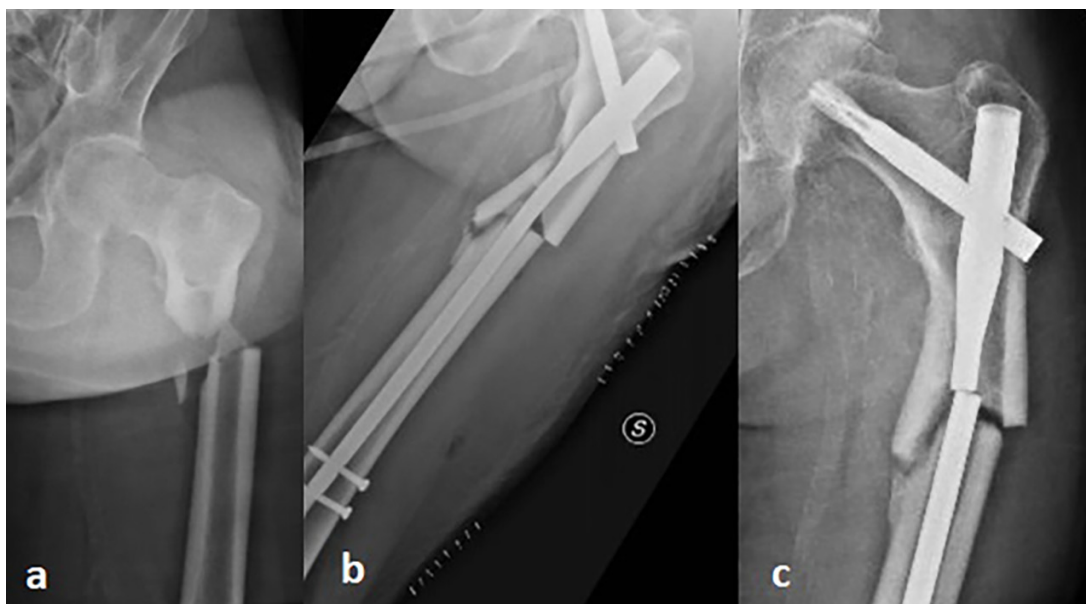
Exemplificative case of subtrochanteric fracture treated with CRIF without cerclage: a, preoperative x-rays; b, postoperative x-rays; c, nail break 9 months after surgery.
